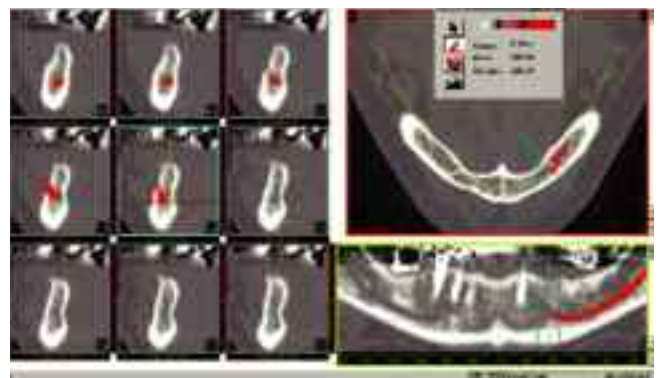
CT scan showing the inferior dental nerve painted in red. See the nerve showing up on the cross-sections and emerging from the mental foramen
